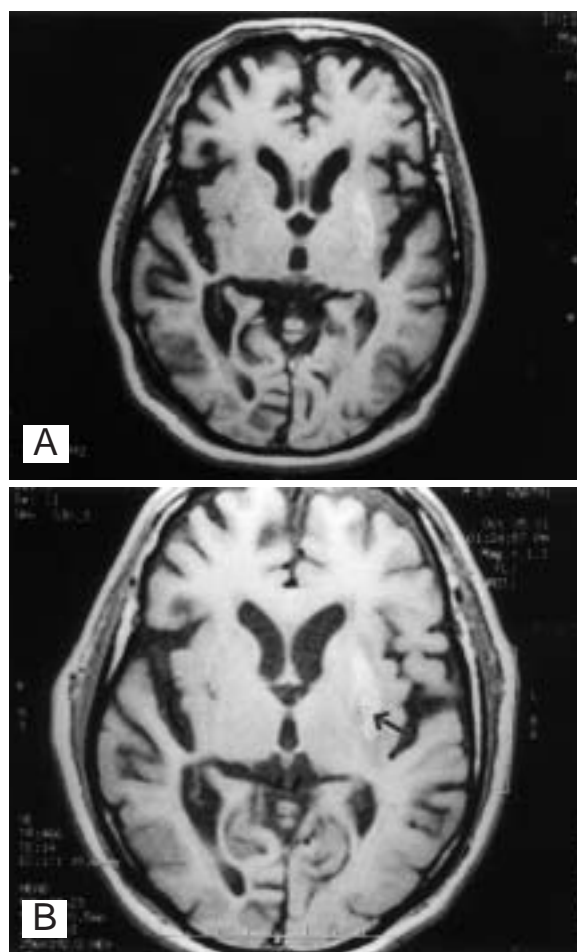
A: Pre-operative MRI of case 1 shows a hyperintensity lesion in the left corpus striatum on T1WI; B: The post-operative MRI on T1WI shows stereotactically created lesions (arrow head) in the left-lateral globus pallidus by radiofrequency electrocoagulation.
